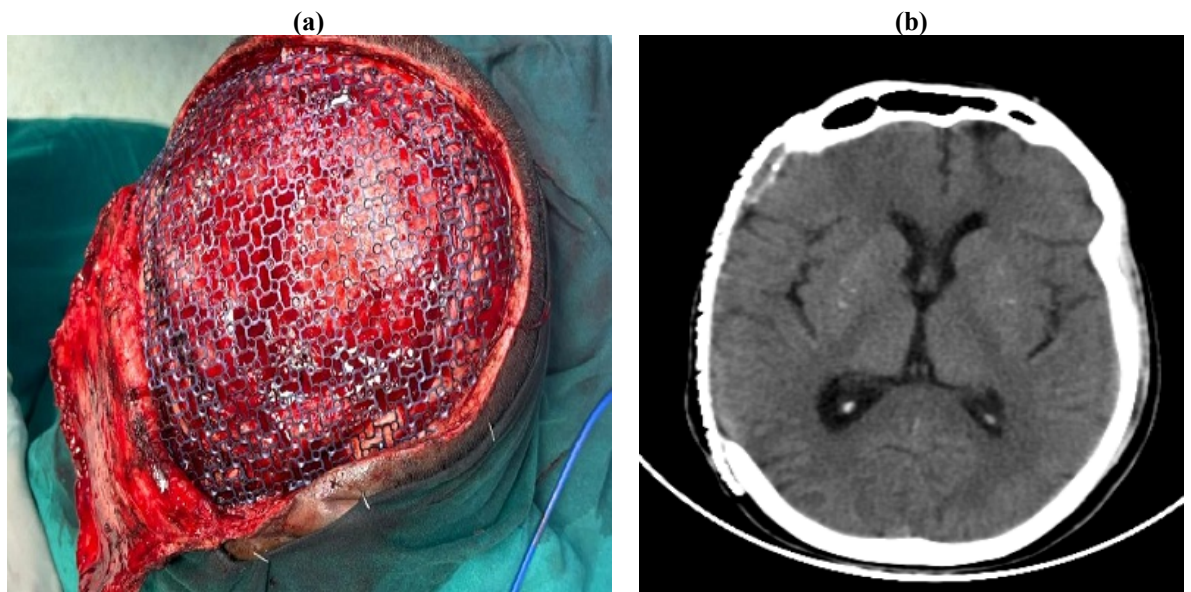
Titanium Mesh cranioplasty (TM) (a): intraoperative image, (b): CT image
